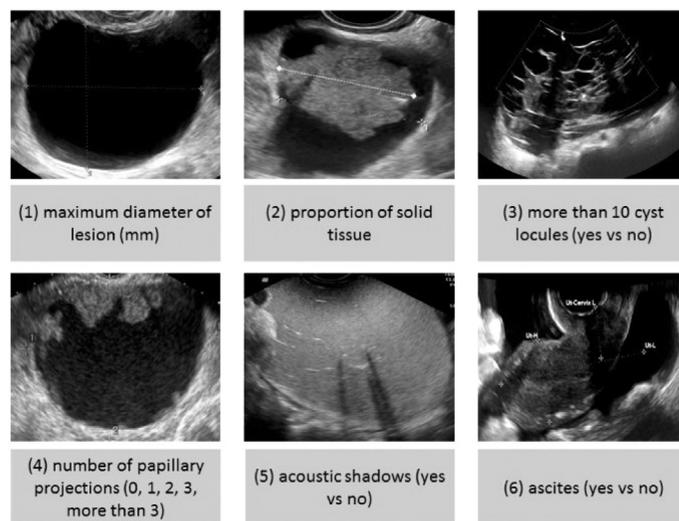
Ultrasound characteristics selected as predictors in the ADNEX model
